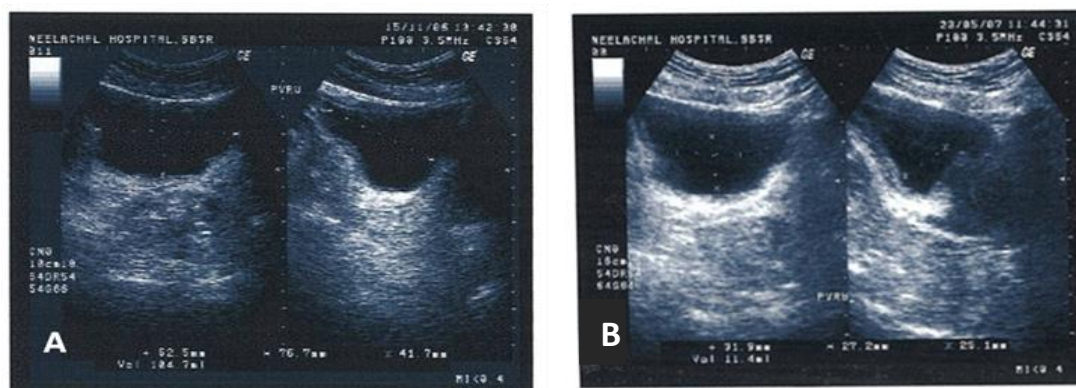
Ultrasonography before treatment with residual urine volume = 104 ml (A) and after treatment with residual volume 11 ml (B).
